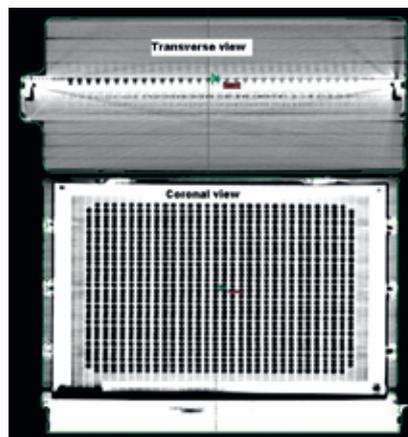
Transverse and coronal view of MatriXX on CT slices.
